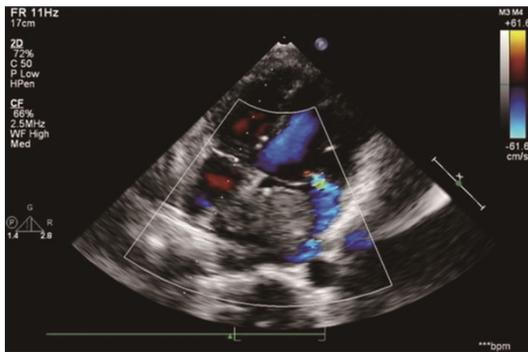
Preoperative color Doppler showed little mitral valve eccentric regurgitation.
